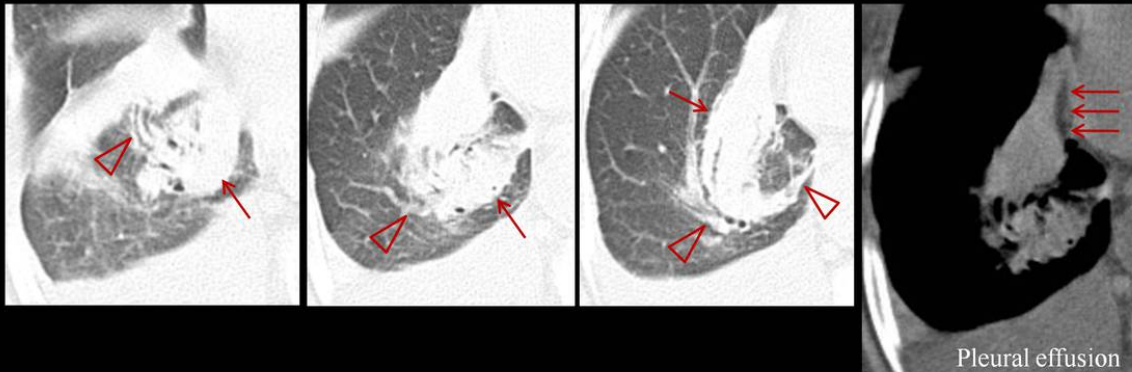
Typical rounded atelectasis associated with pleural effusion. CT scans of three adjacent levels, (a), (b) and (c), show an elliptical opacity (arrows), which has significant contact with the mediastinal pleural surface. Vessels and bronchi curve into the edge of the lesion – “comet-tail sign” (arrowheads). In cine mode it was perceptible a whorled appearance, produced by the crowding of the bronchovascular bundle. Soft-tissue window CT image (d) shows that the opacity has soft tissue attenuation with significant contact with the mediastinal pleura (arrows).
